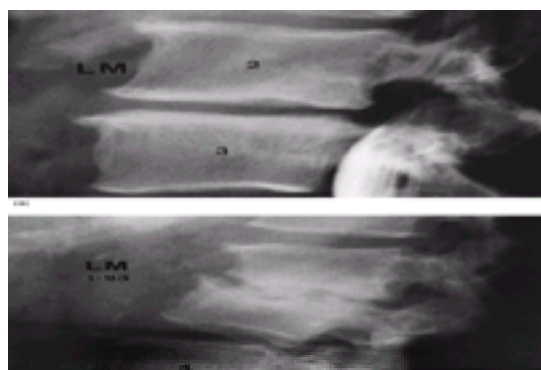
(a) Preoperative lateral myelogram of L2–3 disc herniation.(b) Lateral radiograph of postoperative disc space infection following treatment with intravenous antibiotics. Note the failure of treatment with extensive bony destruction (osteomyelitis) and kyphotic deformity. Early operative intervention would have prevented this degree of progression.
